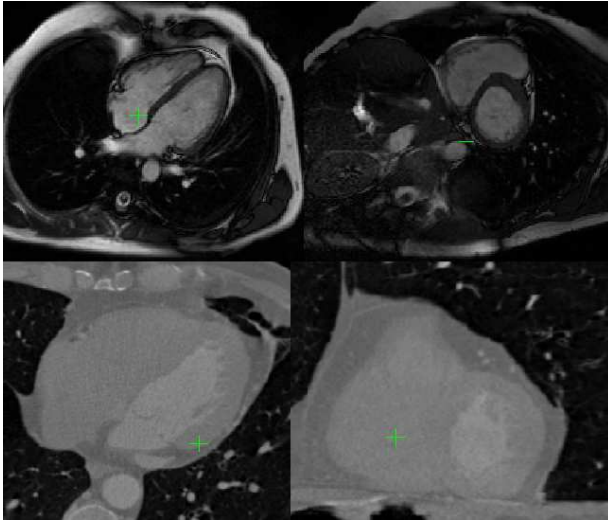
Left ventricle motion model from CT images
